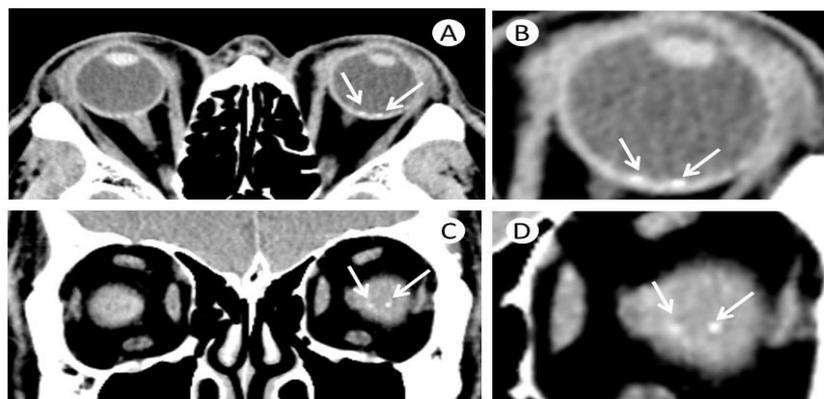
Axial (A and B) and coronal (C and D) CT images
